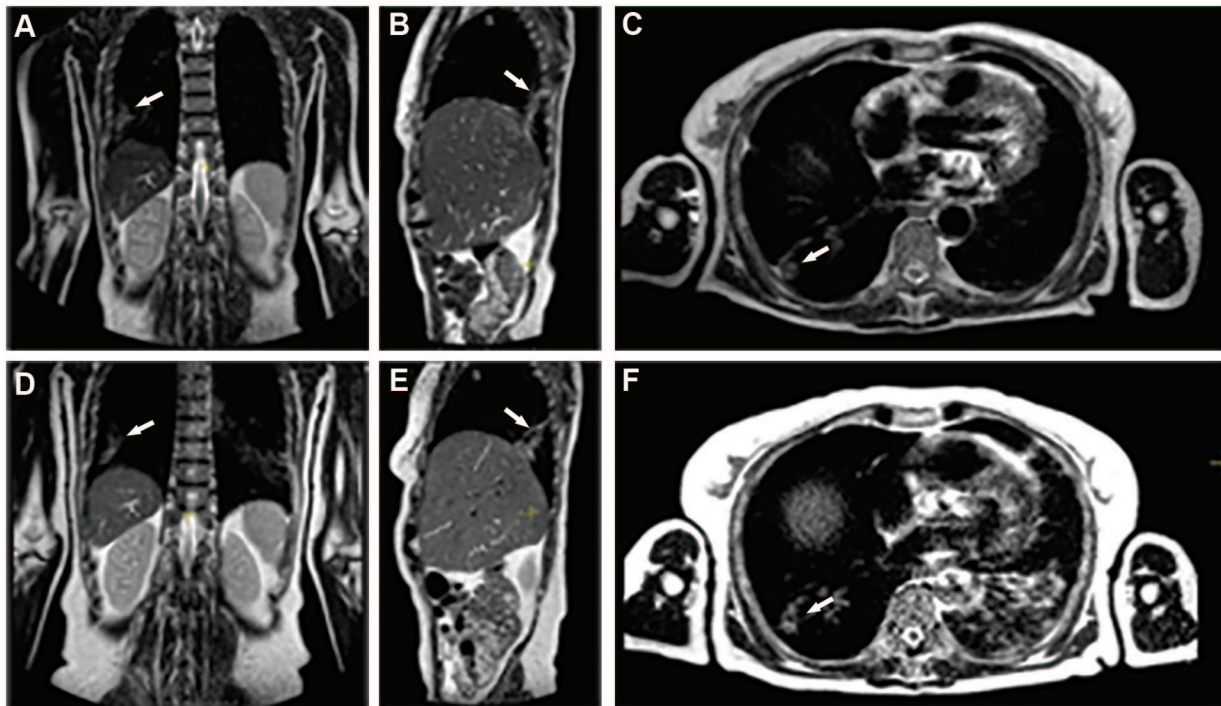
Chest and abdomen MRI follow-up showing the presence of biliary-bronchial fistula (BBF). Arrows indicate the bronchial portion of BBF with signs of perifocal pneumonsclerosis in both images. (A–C) MRI signs of BBF at 4 months after the diagnosis. (D–F) MRI signs of BBF at 9 months after the diagnosis.
